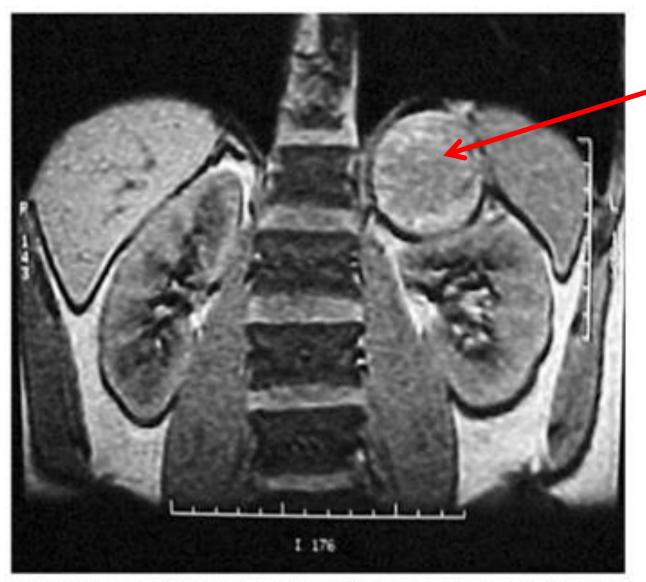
MRI showing large adrenal mass - hypersignal in T2.
